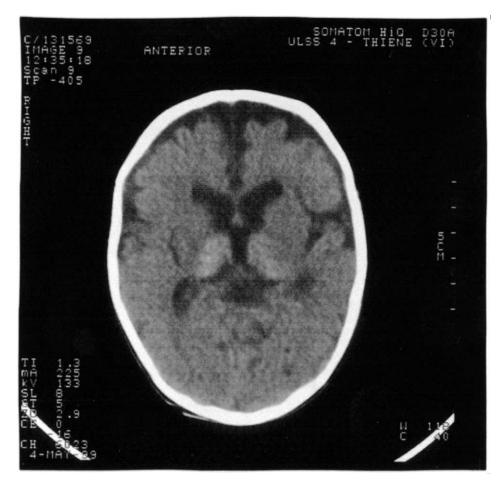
Axial CT image at the age of 2 months shows mild cortical atrophy, ventricular widening and symmetrical hyperdense areas bilaterally in the region of the thalamus.
